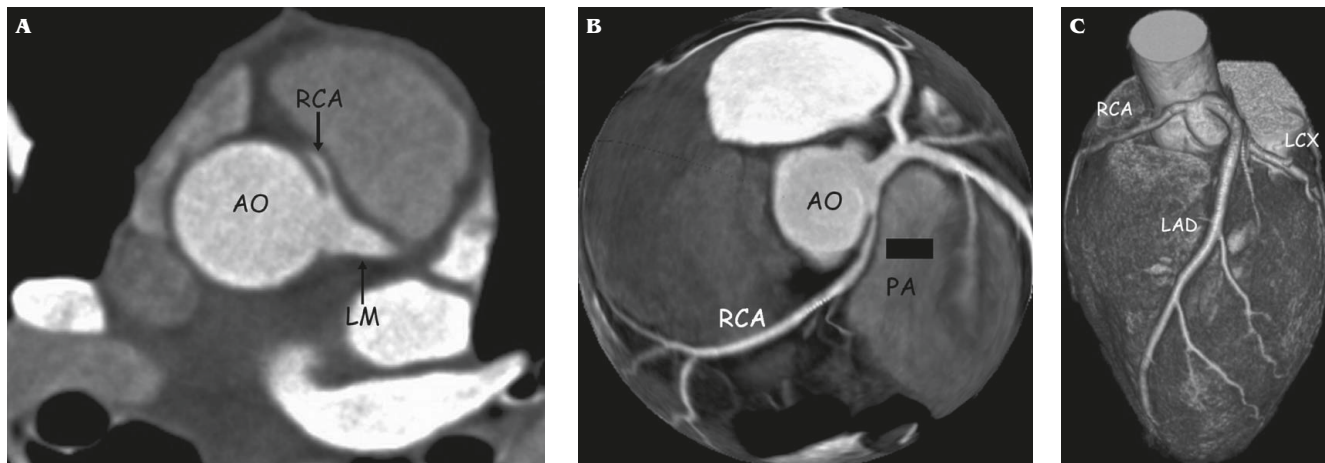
(A) Contrast-enhanced axial computed tomography (CT) shows the right coronary artery (RCA) and left main trunk (LM) arising from the left sinus of Valsalva. AO = aorta. (B) Contrast-enhanced oblique CT shows the RCA coursing between the AO and pulmonary artery (PA). (C) Reconstructed CT with volume-rendering technique shows the three-dimensional structure of the RCA, left ascending artery (LAD) and left circumflex artery (LCX) originating from the left sinus of Valsalva.
